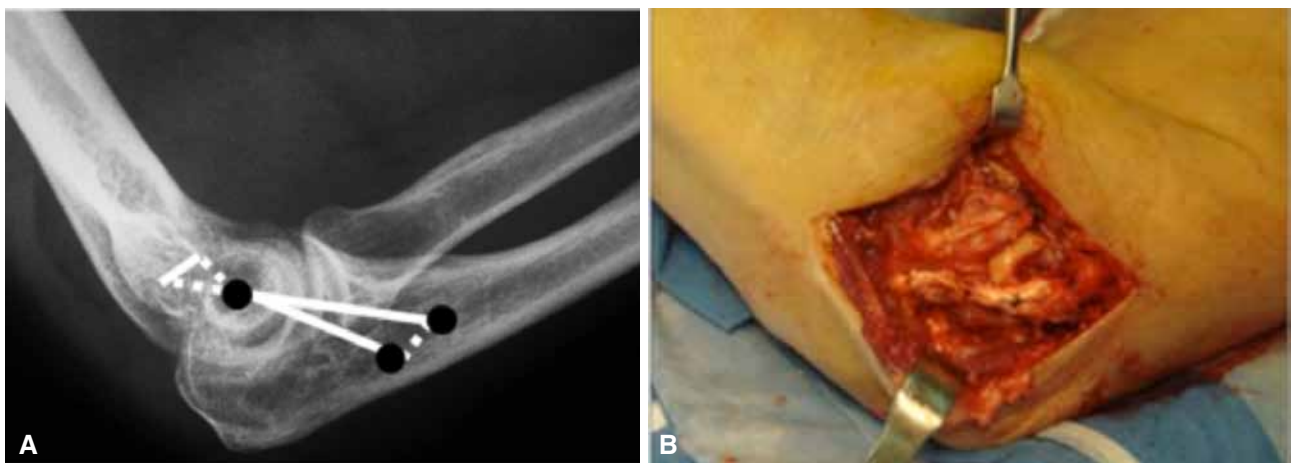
A. X-rays showing the holes ubication. B. Surgical image with palmaris longus tendon.
